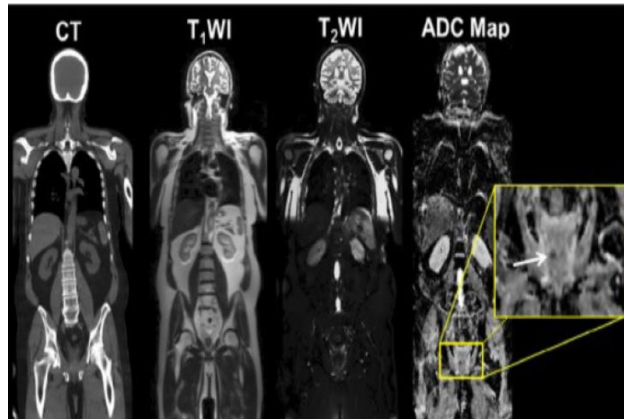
Example of WB-MRI-DWI in prostatic cancer (15).
